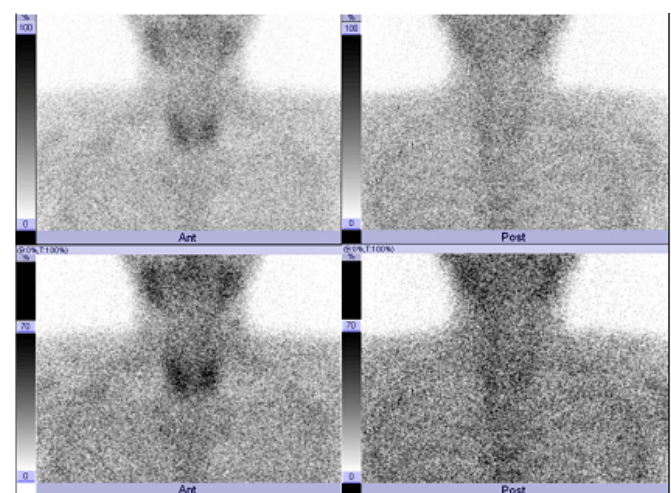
Tc-99m MIBI scintigraphy was performed to diagnose primary hyperparathyroidism and examine other parathyroid glands, but it failed to detect a parathyroid tumor.
